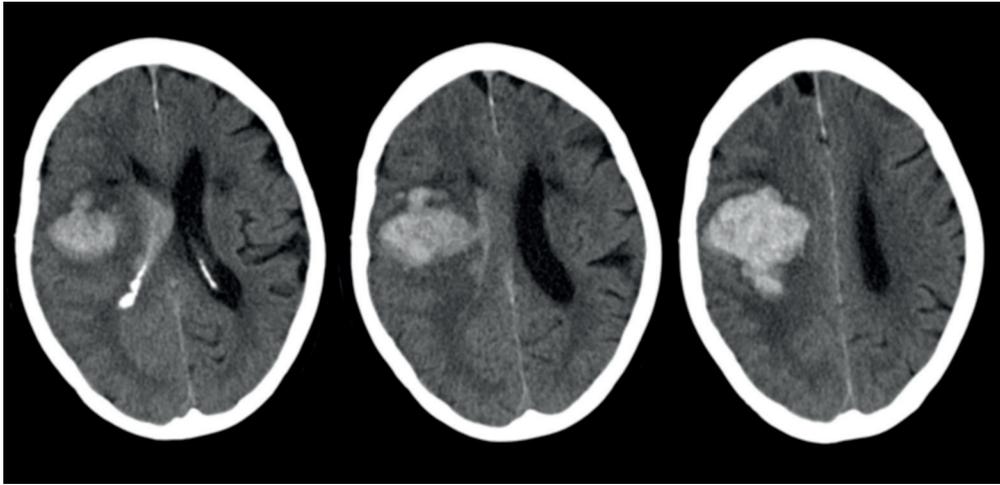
Three images of an axial plane CT-scan of patient GE showing a large hemorrhagic stroke in the right hemisphere. The images follow the radiologist convention of right hemisphere represented on the left.
